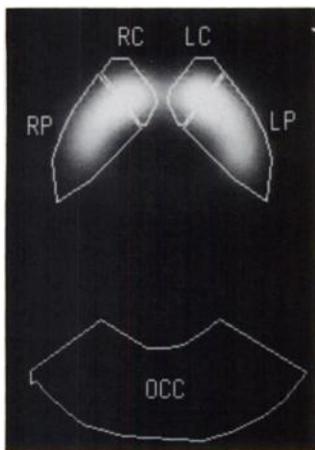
Regions of interest positioned on the [^{123}I] β -CIT SPECT image (displayed in gray scale) at the level of highest striatal uptake. RC = right caudate, LC = left caudate, RP = right putamen, LP = left putamen, OCC = occipital cortex. Left and right caudate and putamen were combined into a single striatal ROI for data analysis.
